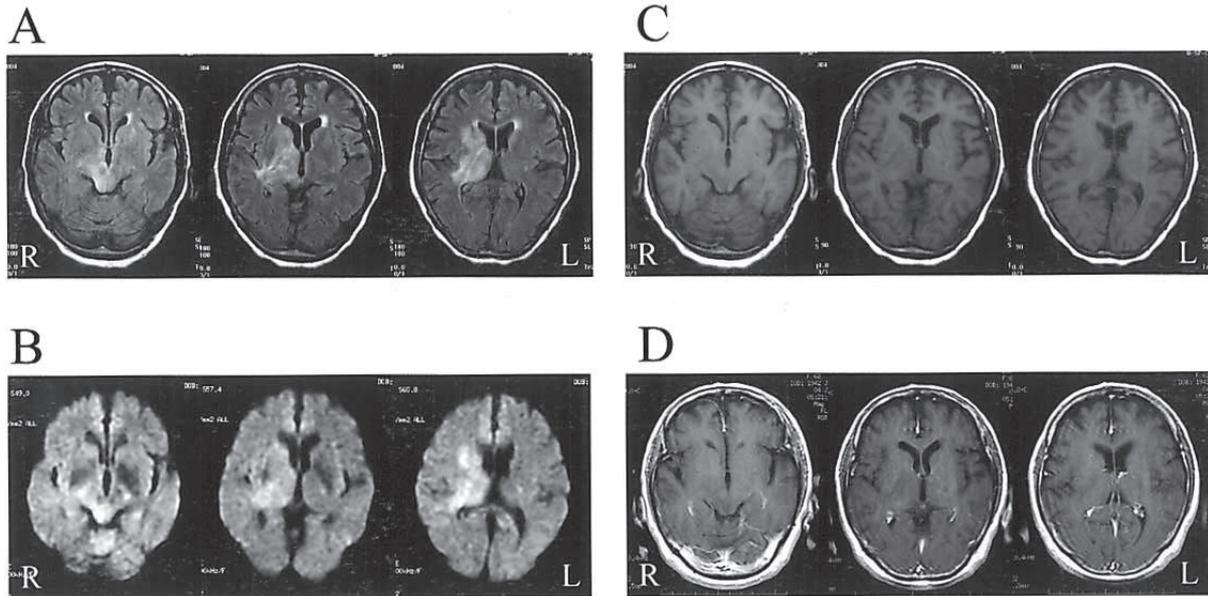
MRI on the day of presentation to a neurosurgical clinic. Fluid-attenuated inversion recovery (FLAIR) (A) and diffusion-weighted images (DWI) (B) showed high-intensity areas in the right basal ganglia (thalamus and caudate head), periventricular white matter and brain stem (midbrain). The lesions were isointense or of low intensity on T1-weighted spin-echo images (C) and showed no enhancement effect after gadolinium administration (D).
